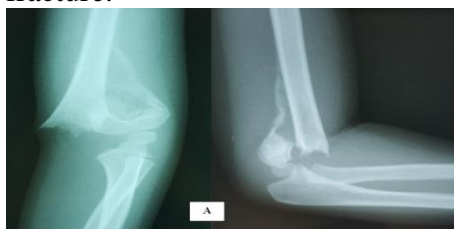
Initial plain radiographs of the left elbow showing a Gartland III supracondylar humeral fracture.
